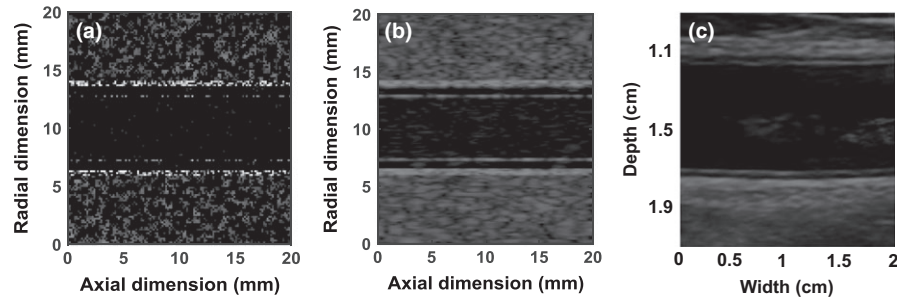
A scatterer distribution (a), the corresponding B-mode ultrasound image (b), and a clinical B-mode ultrasound image (c) with the center frequency of 10 MHz for the CCA with three layers, respectively.
